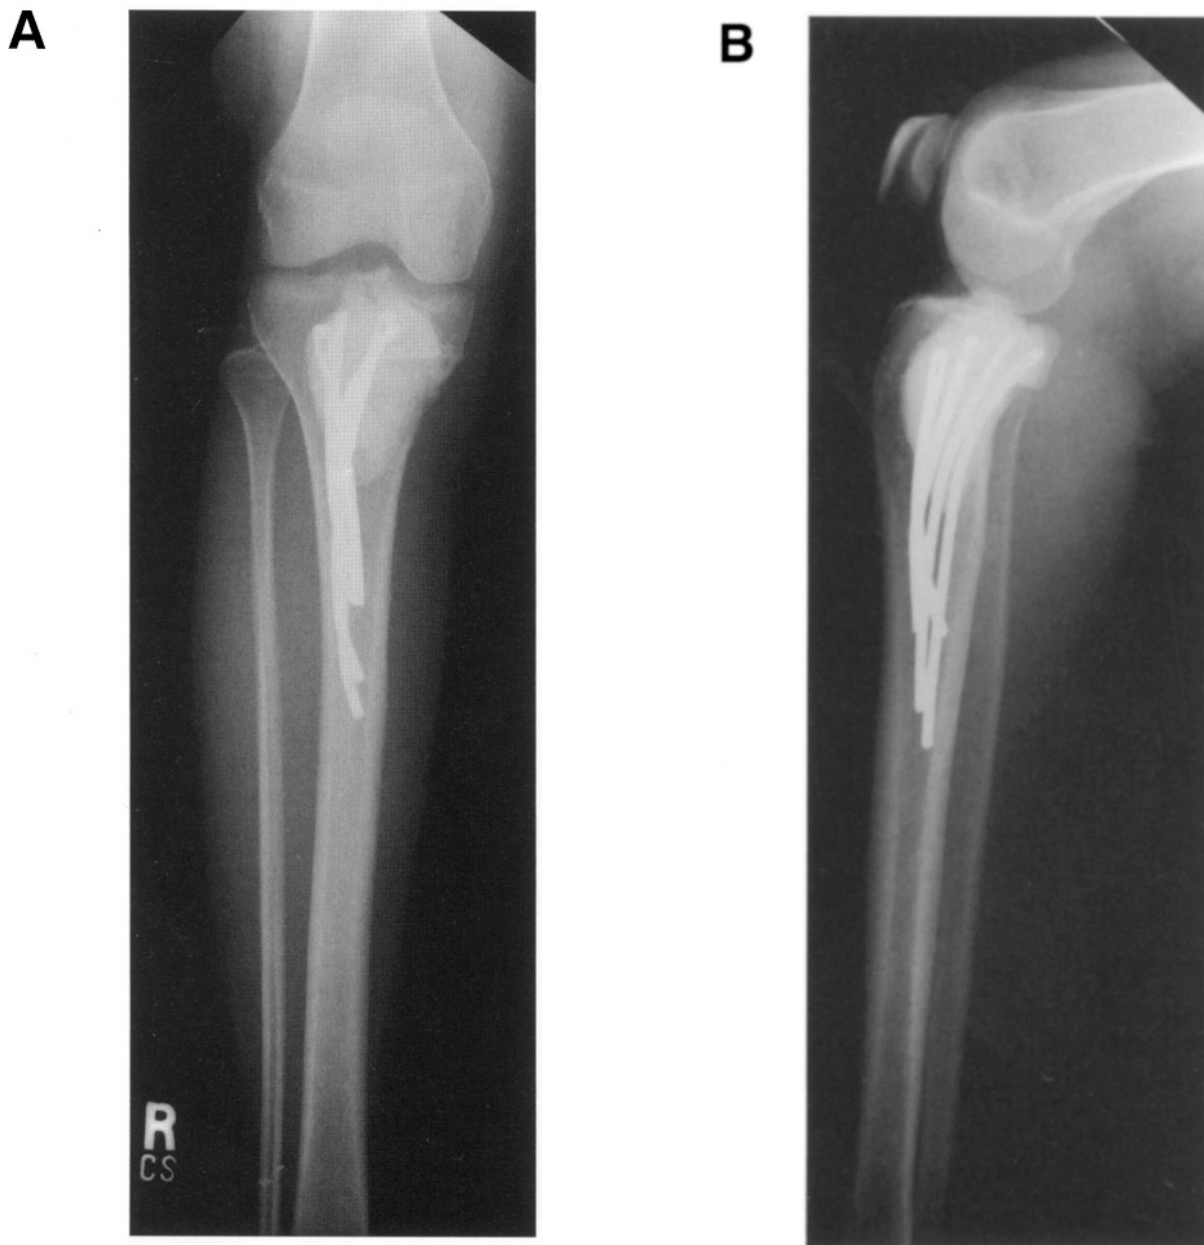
Anterior–posterior (A) and lateral (B) plain radiographs following curettage, cryosurgery, cementation, and internal fixation of a large lytic lesion of the proximal tibia for a metastatic melanoma. Cryosurgery was utilized in an attempt to gain local control in addition to postoperative radiation therapy.
